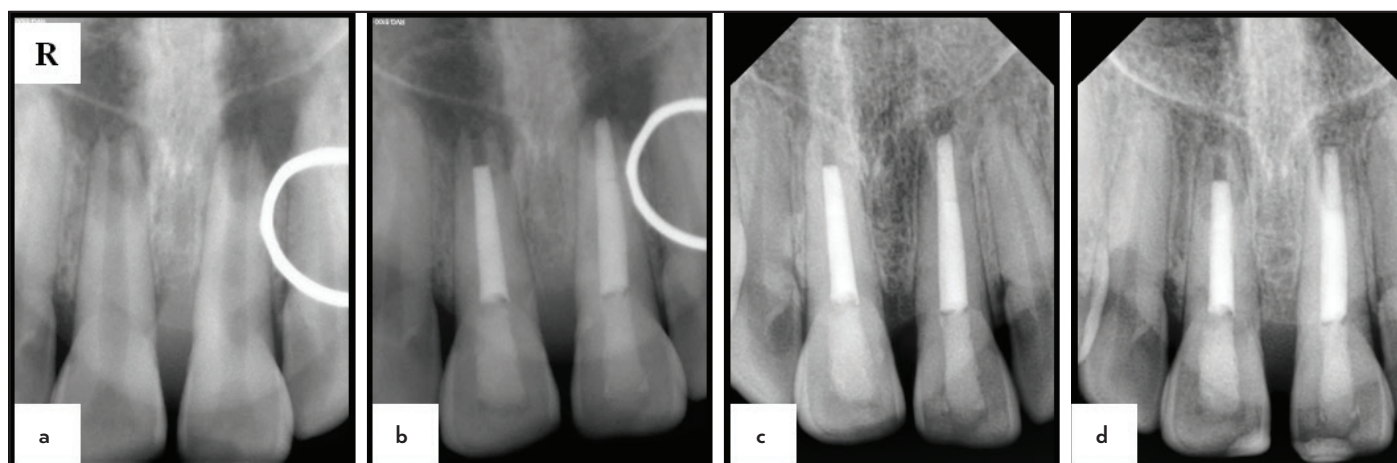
(a) Preoperative intraoral periapical radiograph of teeth #11 and #21 with non-blunderbuss canal and open apex associated PAI scores of 5 and 5 respectively. (b) Immediate postoperative intraoral periapical radiograph of tooth #11 showing MTA apical barrier 2 mm short of radiographic root end and tooth #21 showing MTA apical barrier up to radiographic root end. (c) & (d) Follow up intraoral periapical radiograph exhibiting resolution of the periapical lesion at 12 and 24 months
